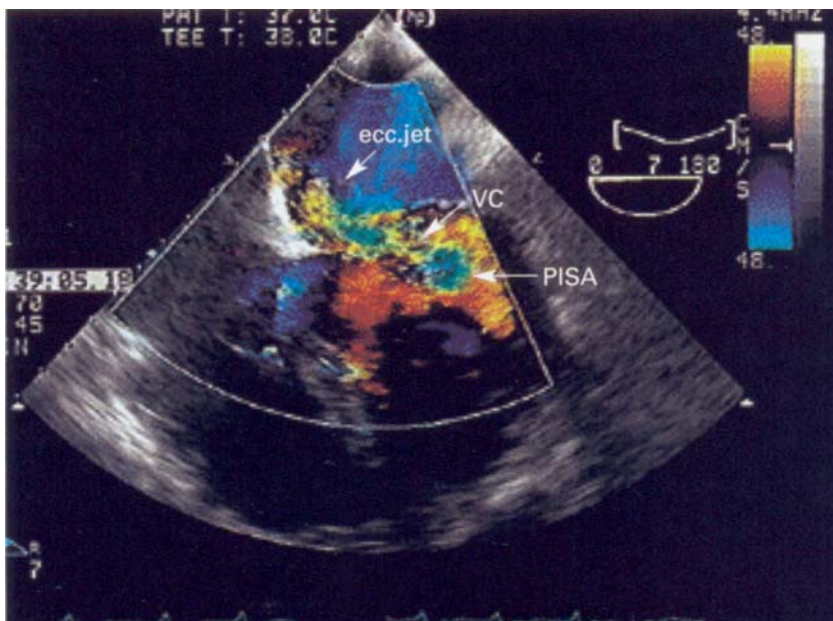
Transoesophageal colour Doppler flow echocardiography in a patient with severe mitral regurgitation. The eccentric regurgitant jet impinges against the left atrial septal wall, resulting in an underestimation of the jet size. The vena contracta (VC) and proximal isovelocity surface area (PISA) are visualised and allow quantification of regurgitant flow. See text for details.
